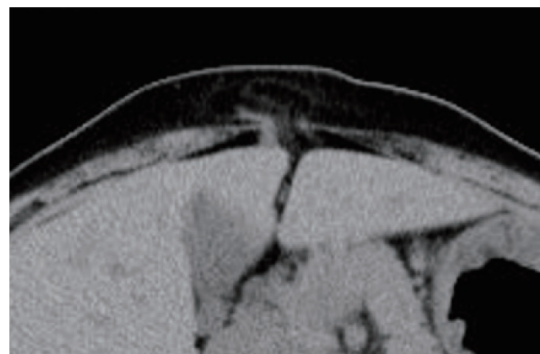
Computed tomography scan shows herniation of adipose tissue and the round ligament through the linea alba in the upper midline.
